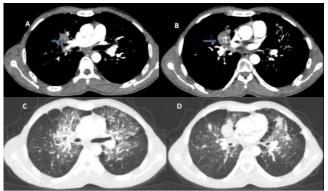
An unenhanced axial chest CT shows a central carcinoid tumor in the mediastinal window obliterating the right middle lobe (a-b), variable sizes of solid masses, and increased size and the number of nodules representing carcinoid tumor and tumorlet (c-d)
